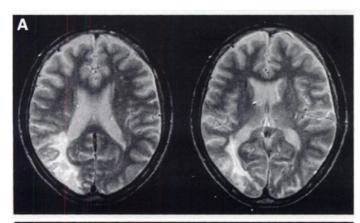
Representative MRI and SPECT images in a patient of deep WS infarct (Patient 1, Type A). (A) MRI shows deep WS infarcts in the centrum semiovale and corona radiata of the right side, while no involvement in the cerebral cortex. (B) SPECT images demonstrate low perfusion and decreased acetazolamide reactivity in the right MCA territory (%INC = 4.7%).
